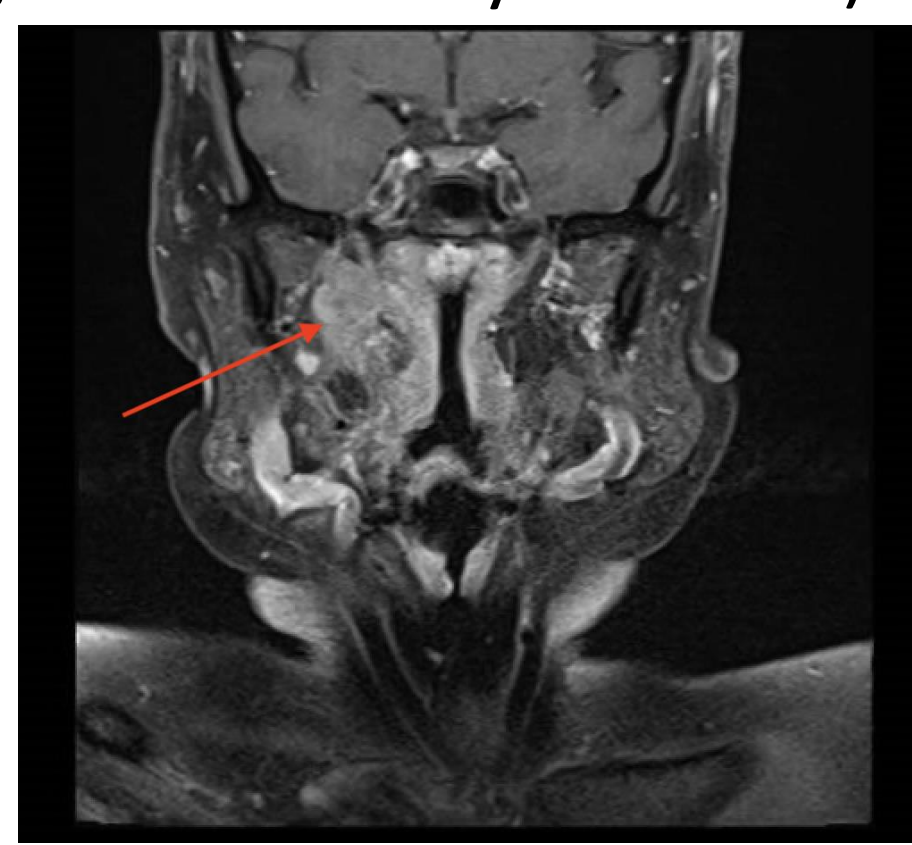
Pre-operative T2-weighted coronal MRI: enhancing mass of right carotid space with anteromedial displacement of hypoglossal nerve and posterolateral displacement of internal carotid artery.
